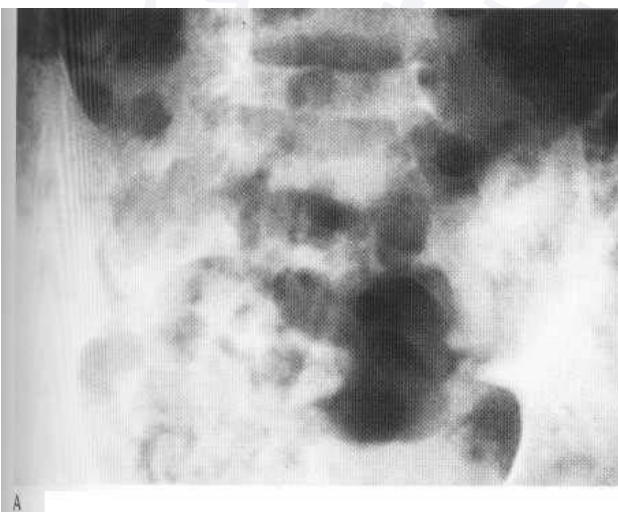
Infective sacroiliitis. (A) There is resorption of bone and sclerosis around the left sacroiliac joint. The radioisotope bone scan (B) shows the increase in uptake, and the CT scan (C) shows the widened joint with areas of irregular bone destruction and soft-tissue swelling. (Courtesy of Professor H. Carty.)
